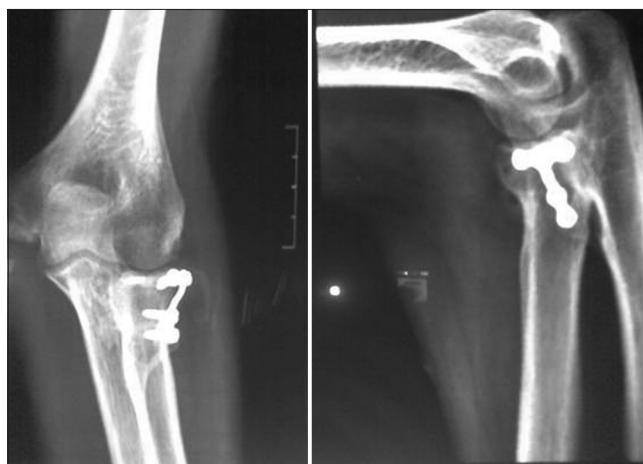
X-ray anteroposterior and lateral views at 6 months showing healing
